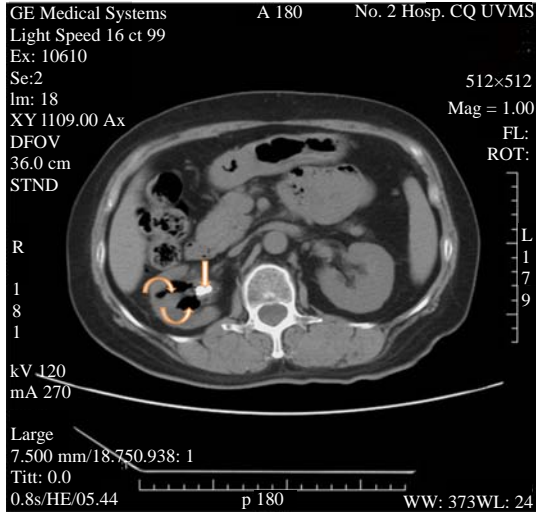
(Case 3) Computed tomography of the abdomen revealed distortion and attenuation of the right renal parenchyma by the gas forming bacteria with gas filled pockets in calyx (curved arrow). A large obstructing pelvic stones (long narrow arrow) (1.2×0.6 cm) and hydrocalycosis are present
